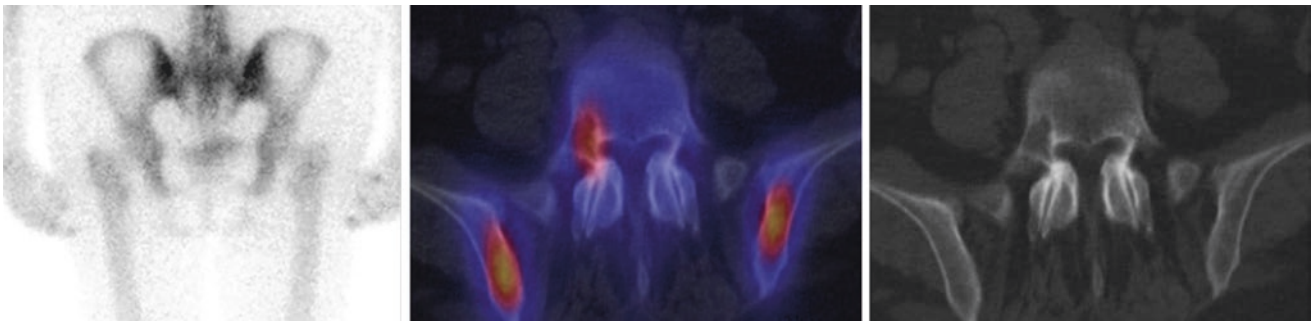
Bone scintigraphy in a 55-year-old patient with breast carcinoma. On the dorsal planar view (left panel), a discrete focus of uptake projects to the lateral aspects of the fifth lumbar vertebral body.
